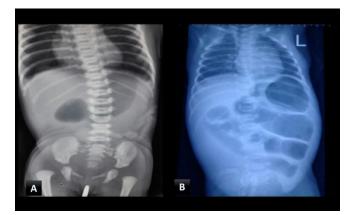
A- X-ray showing Double Bubble in a case of Duodenal Atresia; B- X-Ray showing Dilated proximal bowel loops and absence of distal gas shadow in a case of Ileal atresia
